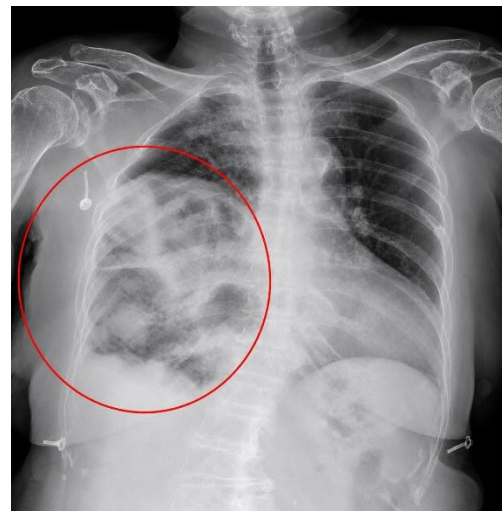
Posteroanterior chest radiograph showing elevation of the right hemidiaphragm with interposed bowel gas, consistent with Chilaiditi sign, together with bilateral pleural effusions and partial right-lower-lobe collapse.
